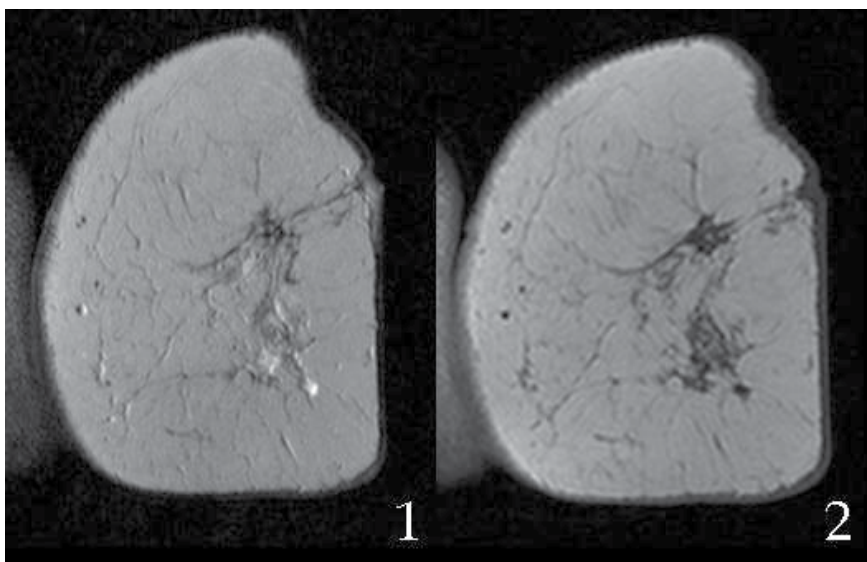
Postsurgical changes in a breast treated for carcinoma. Some areas are hyperintense in T2-weighted sequences (1) and hypointense on T1-weighted sequences (2), corresponding to edema (fluid signal).
